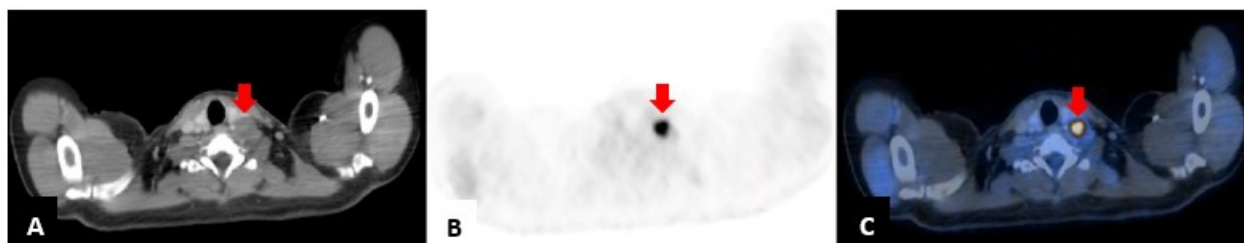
Axial view of the cervical region showing the (A) CT, (B) PET, and (C) Fused PET/CT images of the patient's initial whole-body PET/CT scan of the larger non-enhancing mass in the left cervical area (red arrows).
